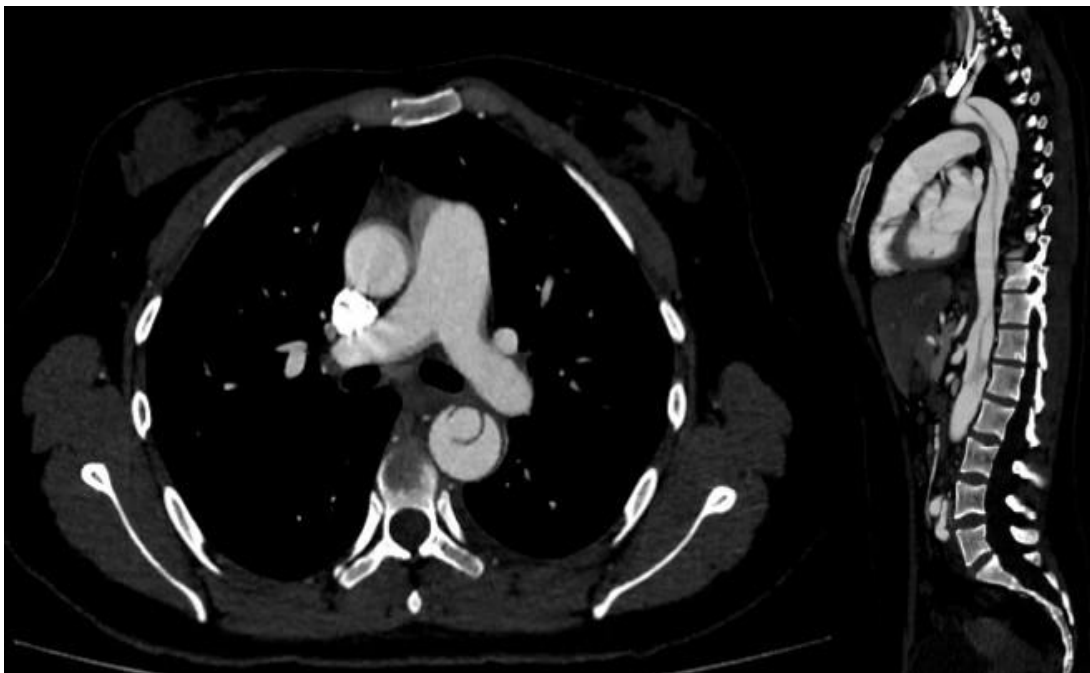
Contrast-Enhanced Chest CT with an Aortic Protocol. Lack of Intraluminal Contrast Opacification is seen from the Aortic Arch to the Abdominal Aorta, Delineating an Intimal Flap Consistent with a Stanford Type B Aortic Dissection.
